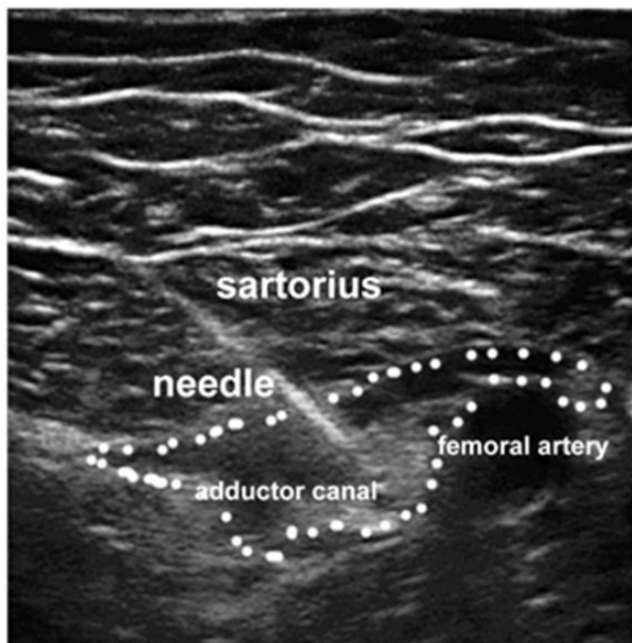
Ultrasound image of the site of ropivacaine injection (white dots).
